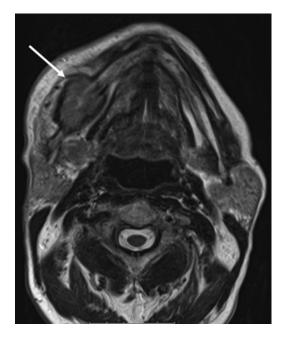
Nine months after radical cystectomy a patient presented with a lump on their mandible. MRI showed a destructive soft tissue mass centred on the body of the right mandible (arrow). PET confirmed a solitary site of disease, which was proven to be recurrence at biopsy. The patient responded well to chemotherapy.
